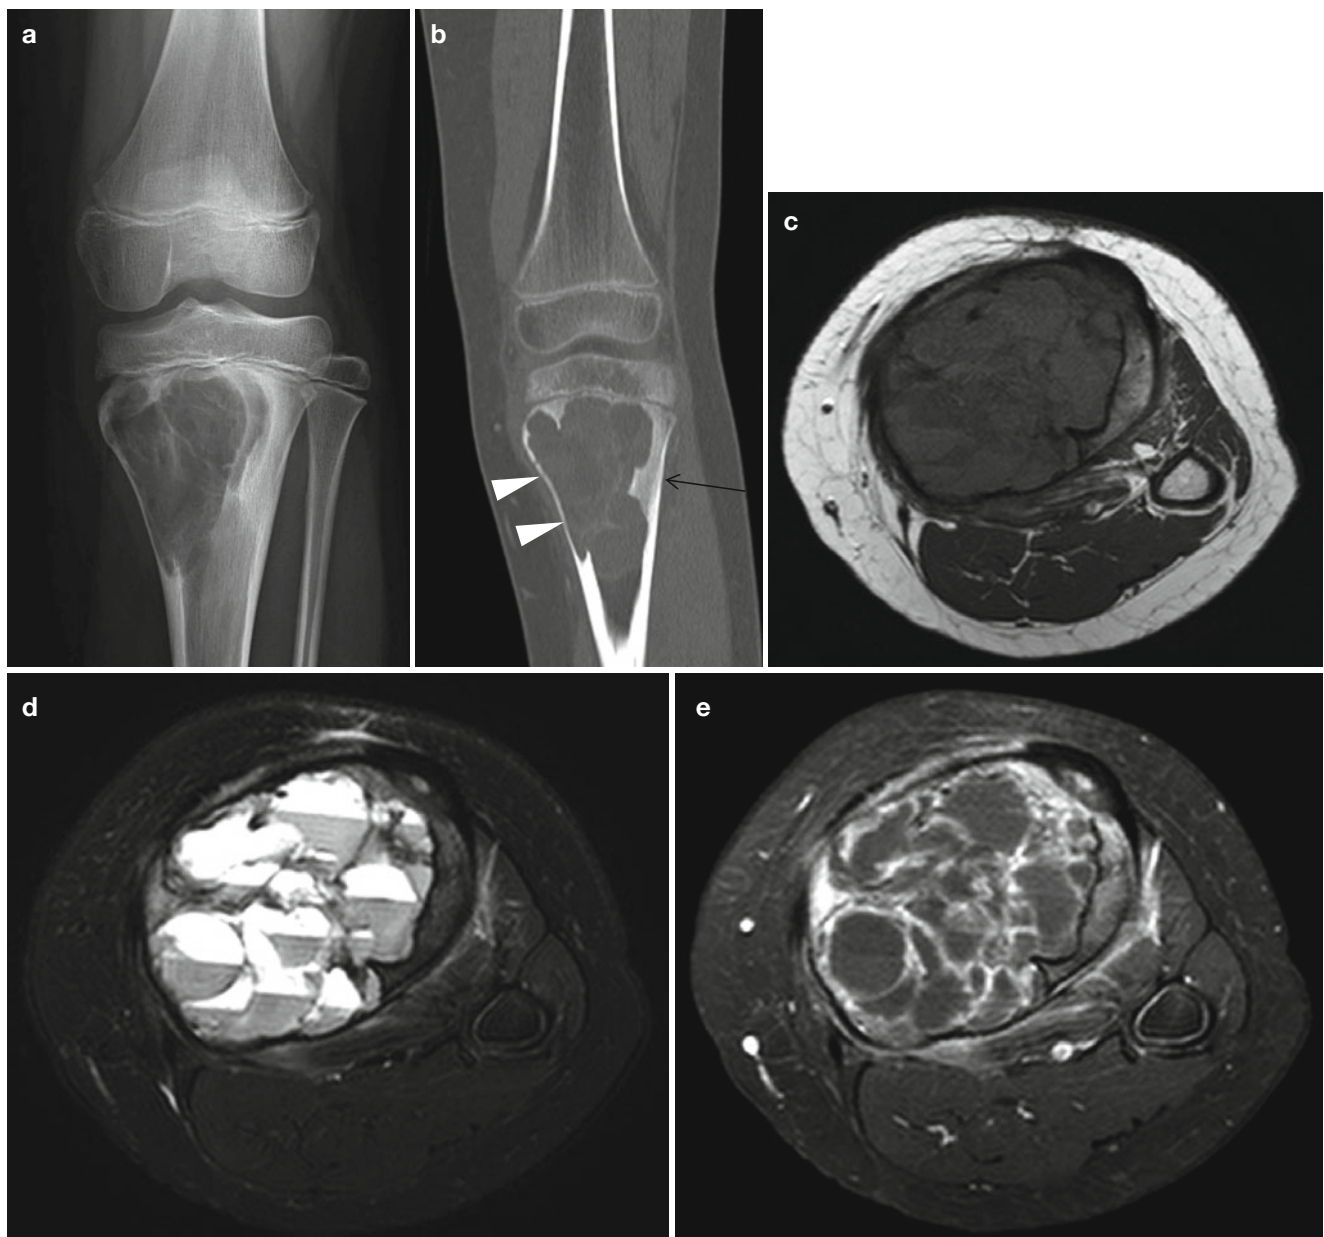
Aneurysmal bone cyst in a 14-year-old girl. (a) Left-knee AP radiograph shows a well-demarcated cystic lesion with suspicious intervening septations in the left proximal tibia abutting the physis. (b) Coronal CT scan reveals intramedullary cystic lesion with lobulating contour and internal fine septations. Endosteal scalloping is clearly seen
